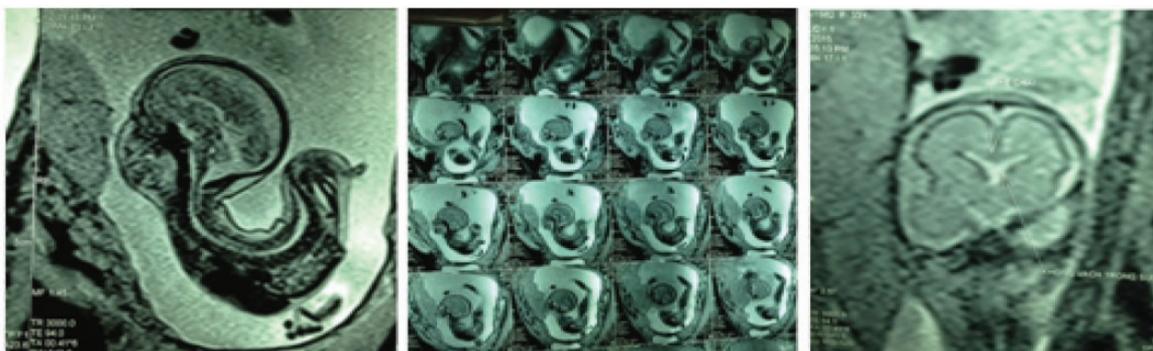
Persistent distorted spine with scoliosis and absent cavum septum pellucidum in MRI. MRI: magnetic resonance imaging.
